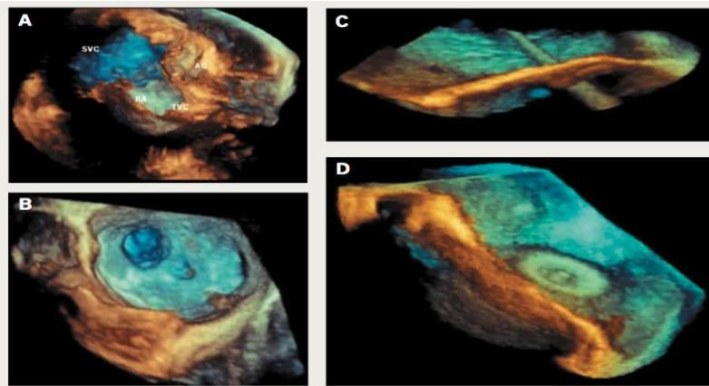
3D echocardiographic images in closure of atrial septal defects (ASD). A & B: improved identification of size, shape, location, orientation and multiple orifices pre-procedurally. C: delivery catheter view across the defect. D: positioning of the left atrial disc and retraction against the septum.
